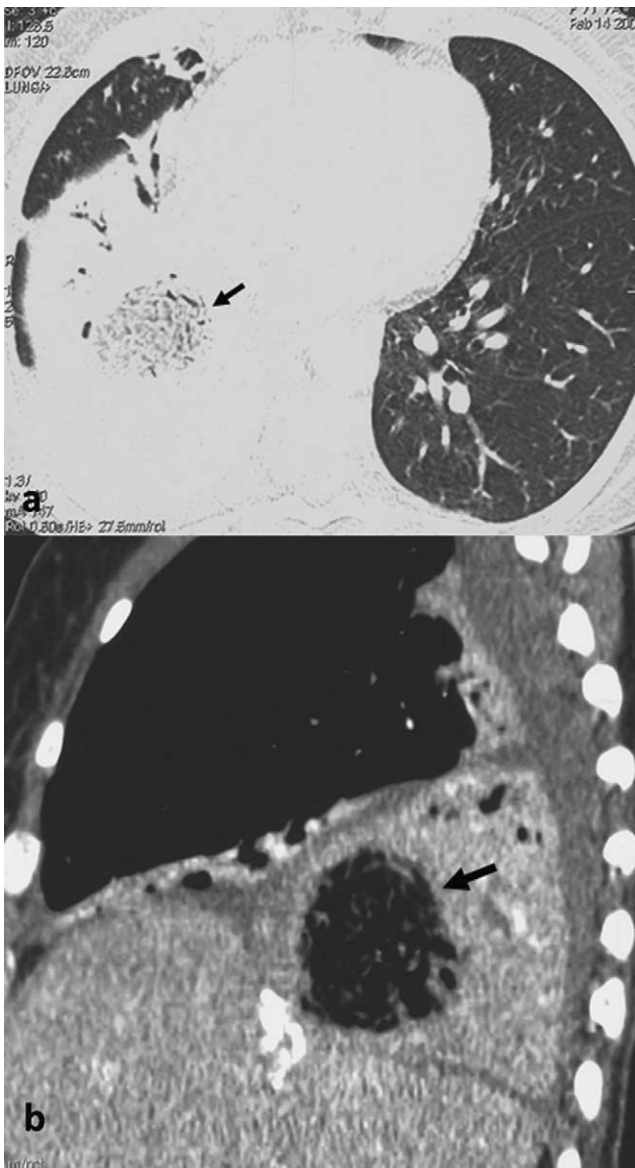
(a) CT showing a mass containing gas bubbles and internal wavy structures of the right inferior lobe (arrow). (b) CT sagittal reconstruction showing pulmonary mass (arrow) in face of hepatic scar of echinococcal cyst resection.
